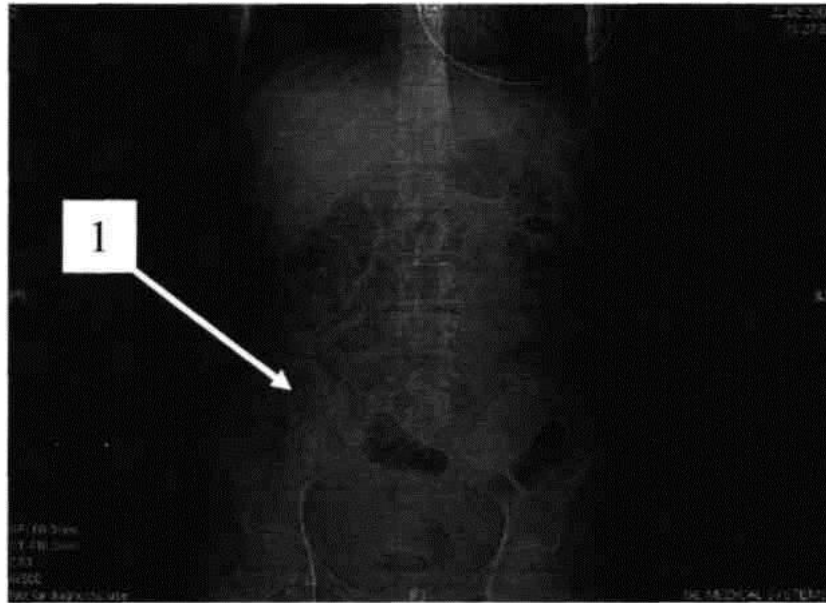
CT in the native form of the patient A., 3 years 5 months, with the acute form of late adhesive intestinal obstruction, the cross-section. 1. Testing of bowel loops; 2. Collapsed loops of intestine.
